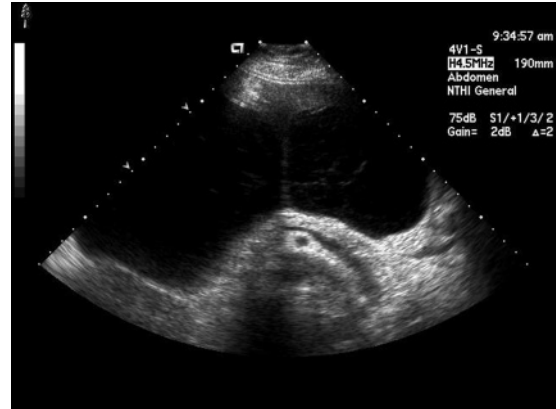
Biloma by ultrasound (courtesy of Eric Walsler MD, Department of Radiology, Mayo Clinic Jacksonville).
